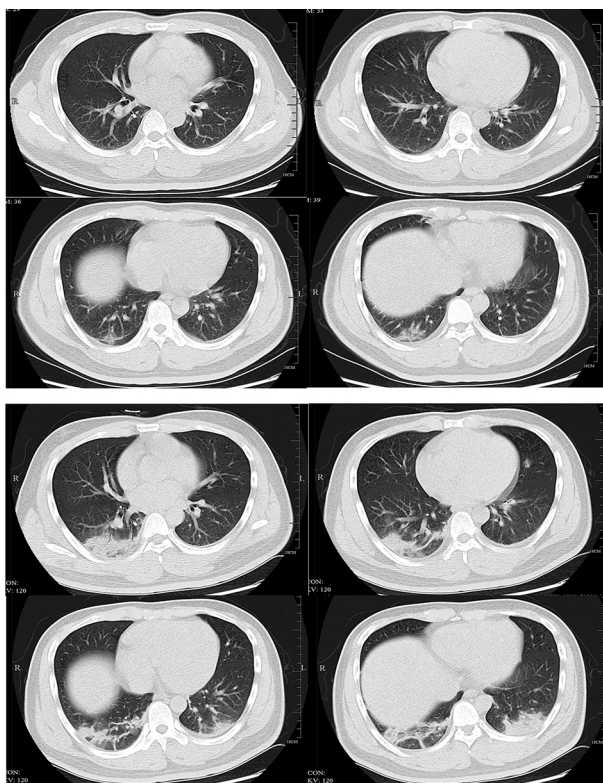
Transverse chest computed tomograms from a 32 year old man, showing ground glass opacity and consolidation of lower lobe of right lung near the pleura on day 1 after symptom onset (top panel), and bilateral ground glass opacity and consolidation on day 7 after symptom onset (bottom panel)
